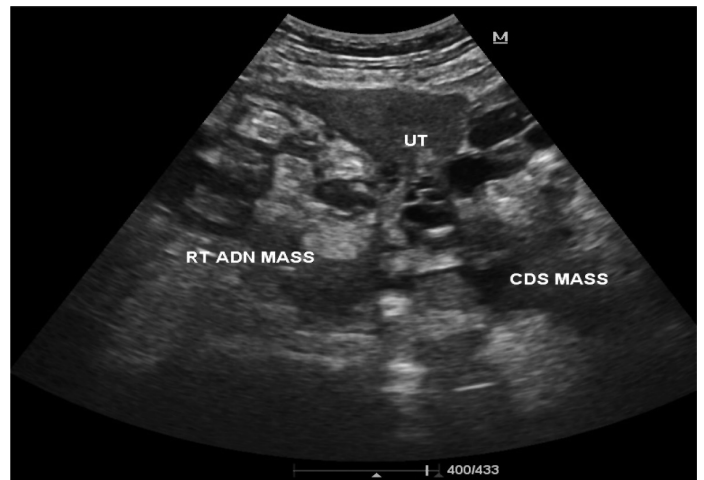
Transvaginal ultrasound, transverse view of the uterus, right adnexal mass and cul de sac mass. At the right adnexal area (RT ADN MASS) is a heterogenous predominantly solid mass measured 9.3 x 10.6 x 8.1 cm. A cul de sac mass (CDS MASS) with heterogeneous predominantly solid measured 6.9 x 8.5 x 4.5 cm
